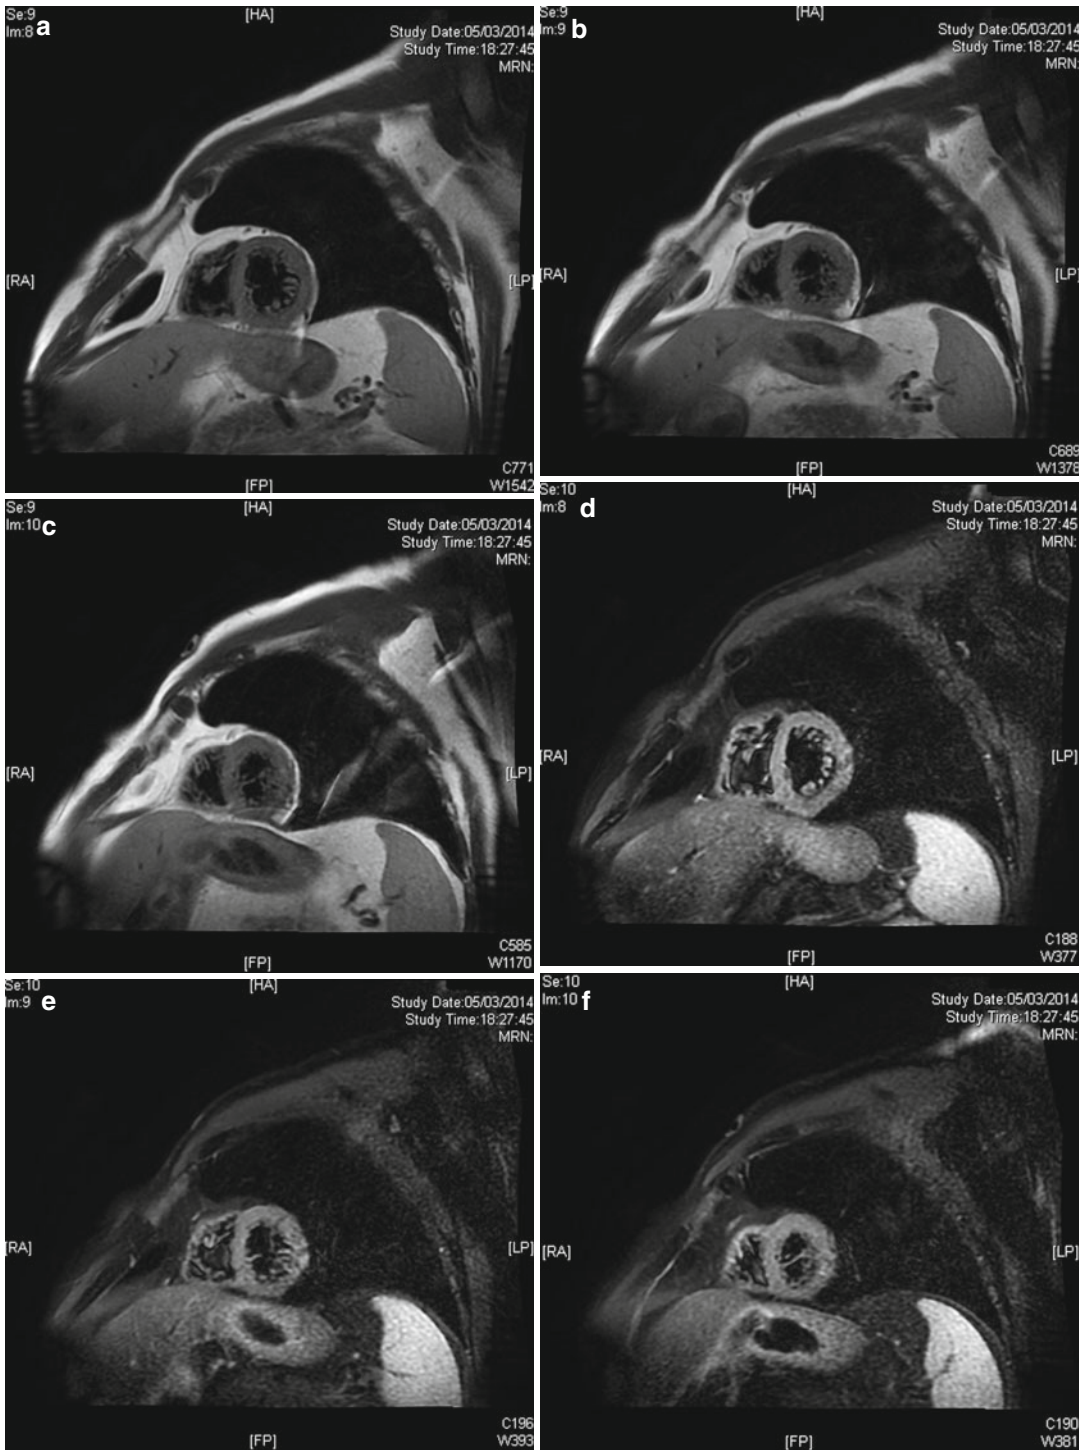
(a–f) Cardiac RMN, short-axis view of the left ventricle in different levels (T1-weighted black blood imaging). In these images, trabecula’s extension to the side wall is visible
